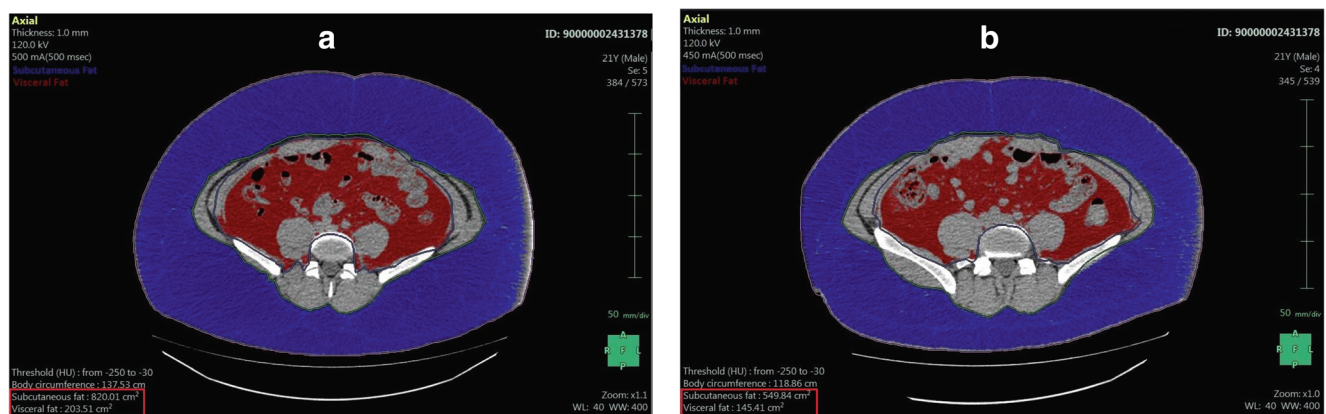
Abdominal CT axial view (2D) in a LSG patient: (a) before operation; (b) 6 months after operation. Subcutaneous (blue) and visceral (red) fat surface areas (cm²) are represented in the box at the left lower corner of each image
